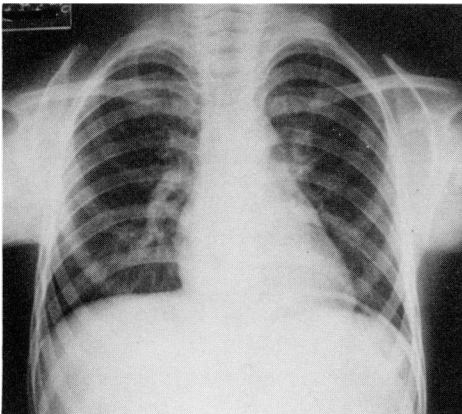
Chest X-ray film 14 days later (Case 5).
